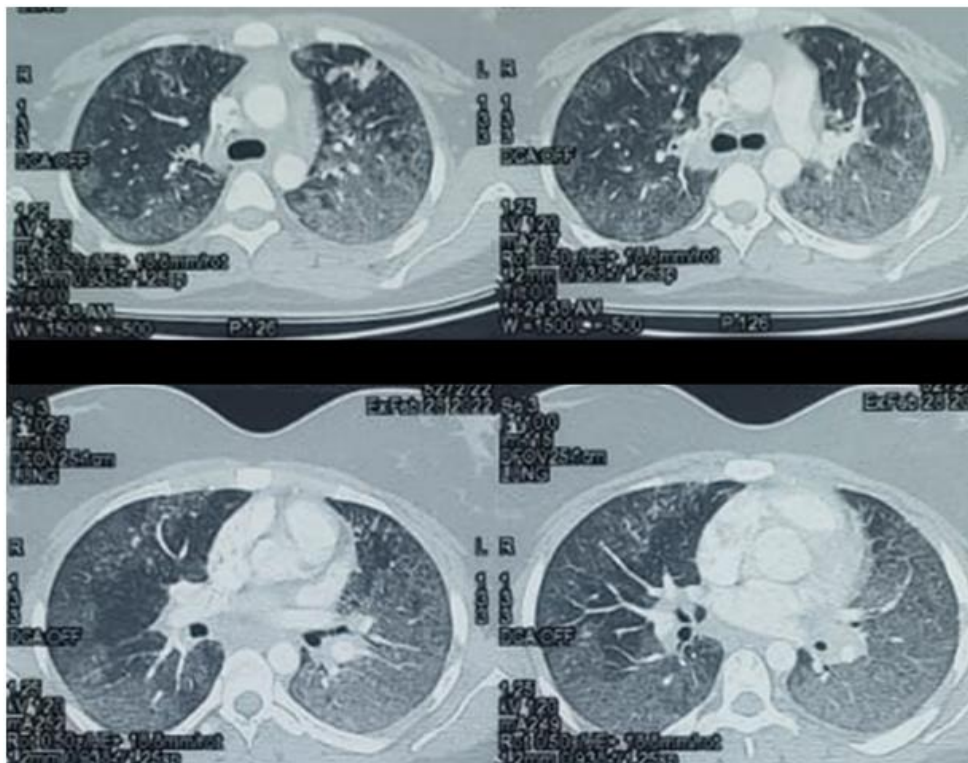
Chest CT scan showing diffuse ground-glass appearance
